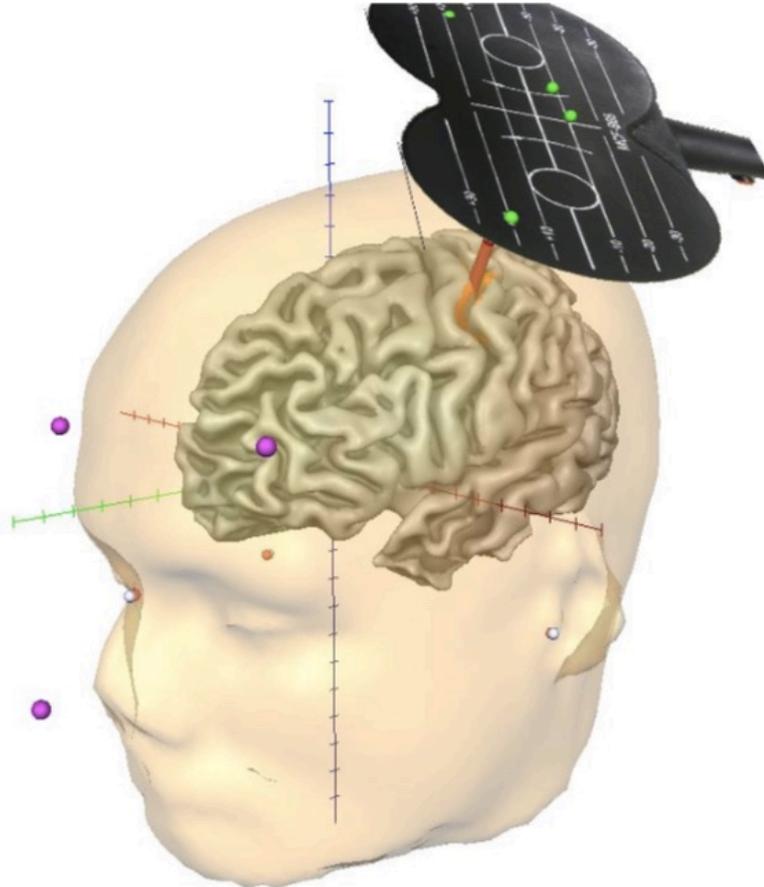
This picture shows the 3D reconstruction of a participant's head and brain with the neuronavigated TMS coil placed over the functionally identified left primary motor cortex (orange region). The grey dots on the head mesh are reference points that set up the virtual individual's spatial coordinate system. Their real-world equivalent is determined with a digitizing pen (orange dots). The coordinate system of the virtual and real head is then co-registered (overlay of grey and orange dots). The purple dots represent the ultrasound senders, which are attached to the participant's face and are continuously transmitting ultrasound waves to a respective receiver. After co-registration, the recorded information from the ultrasound transmitters enables the software to detect the head's real-time location in space. Furthermore, the TMS coil is co-registered in the same way: reference points are specified in virtuality and reality (again with the digitizing pen; green dots), which are then overlaid. The stimulation coil is also equipped with ultrasound transmitters, thus the location of the coil can be tracked in real-time. This allows the optimal positioning of the coil and hence an optimal stimulation. Figure used with the consent of Philipp Seidel, for original see Seidel, 2019.
